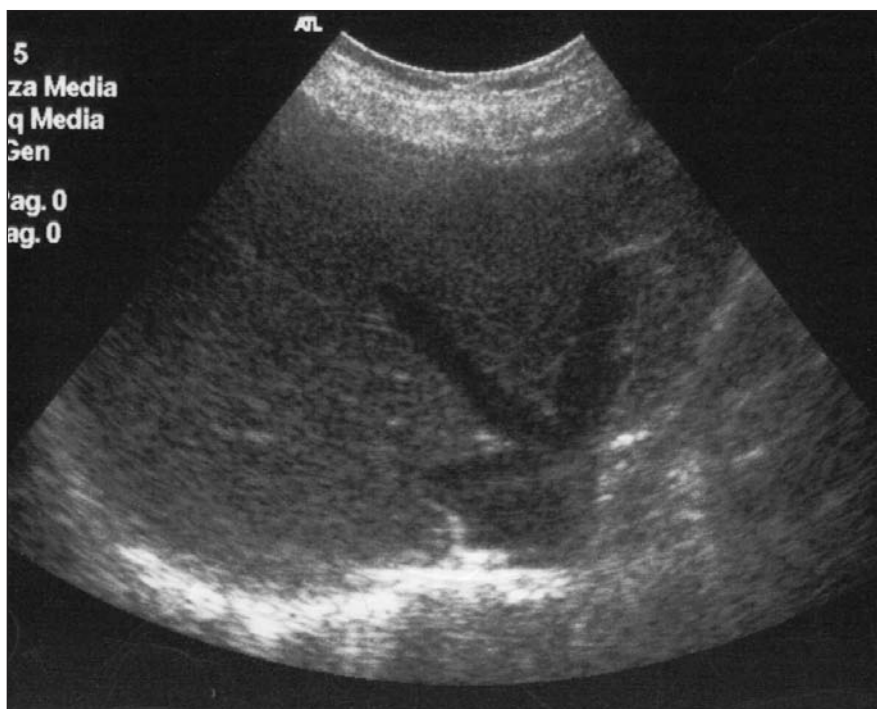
Ultrasound image of the patient's liver.
